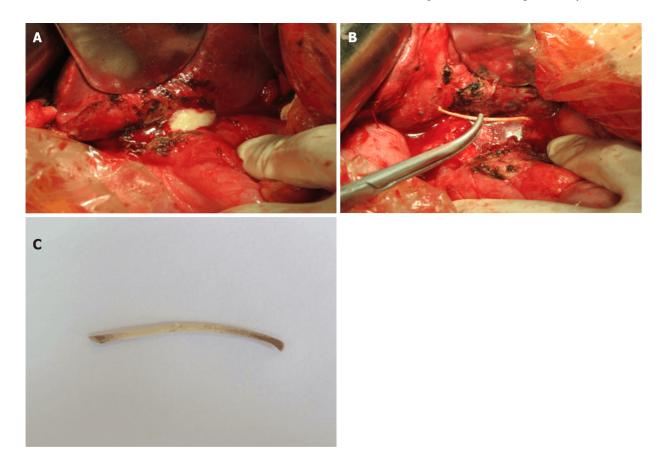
Intraoperative gross findings. A: A large multi-lumen thick-walled abscess measuring approximately 9.0 cm × 8.0 cm × 8.0 cm × 8.0 cm is seen anterior to the caudate lobe of the liver and superior to the head of the pancreas, with no bony foreign body seen within it; B: Ultrasonographic imaging showing an additional abscess cavity deep within the large abscess, in which a foreign body, seen here grossly, was found deep behind the portal vein, measuring about 5.0 cm × 4.0 cm × 4.0 cm; C: Upon removal, the bony foreign body was identified as a fishbone about 4 cm in length and 0.3 cm in diameter.
